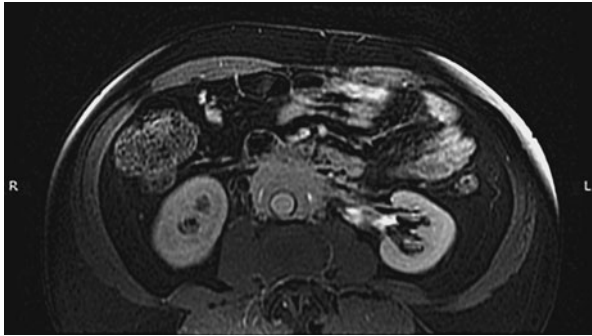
Magnetic resonance imaging scan of the kidneys showing retroperitoneal fibrosis. Fibrotic tissue is noted surrounding the aorta and the left renal vessels.
